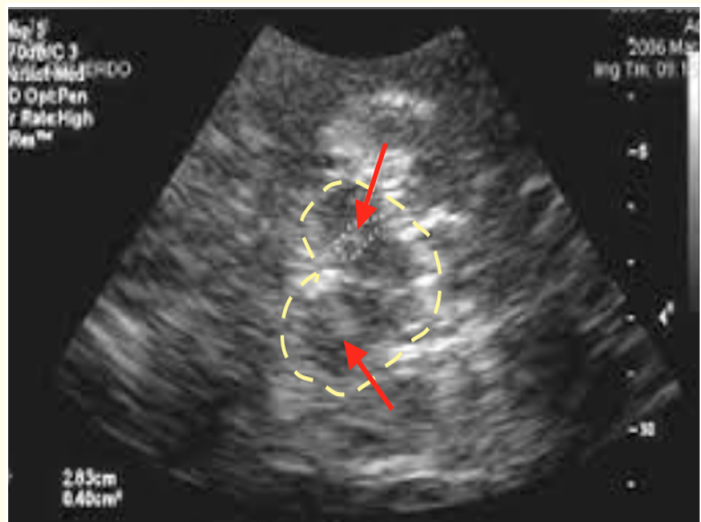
Mesencephalic ultrasonography. The cerebral peduncles and echogenic features of the SN are shown (red arrows).
